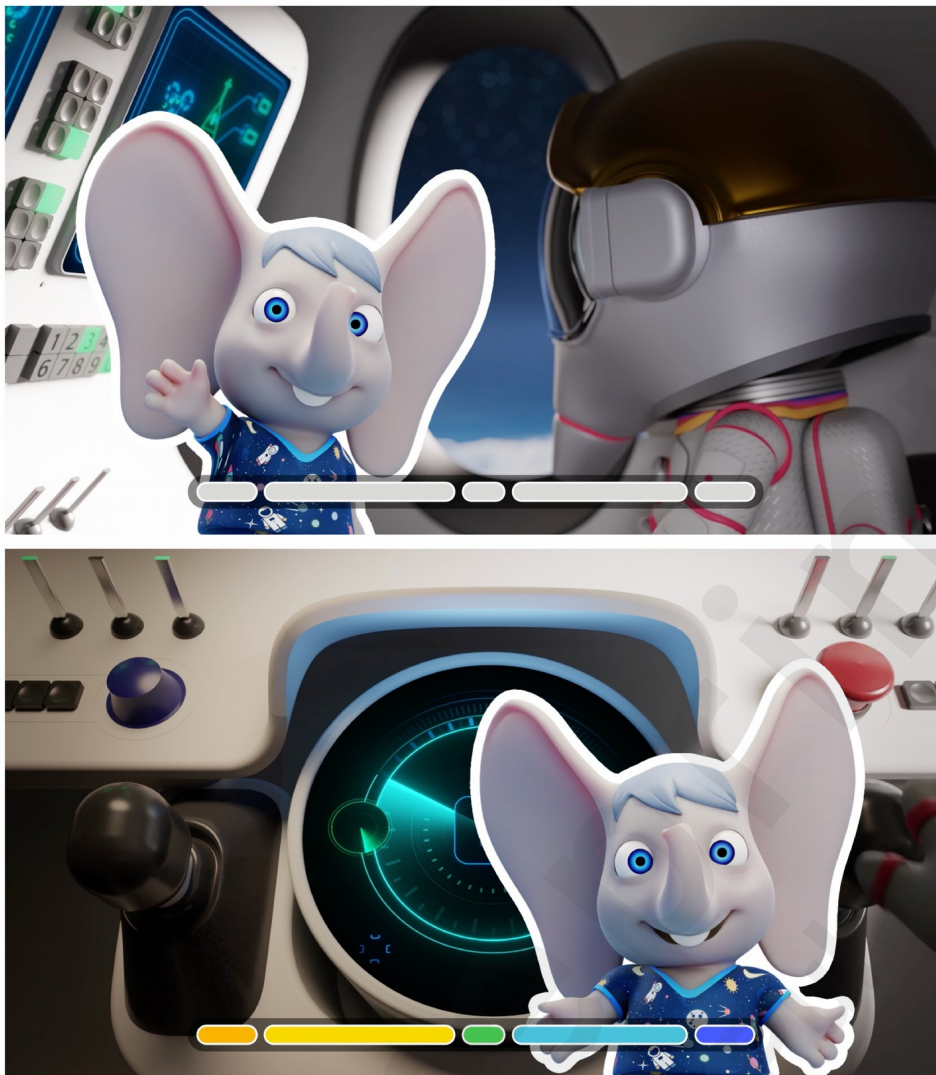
At the start (top) and end (bottom) of the MRI examination Ollie the elephant actively welcomes and says goodbye to the child.
